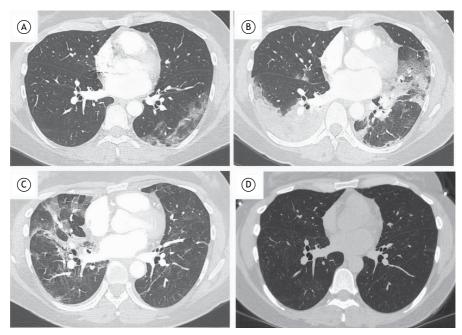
HRCT scans taken 14 days, 24 days, and 33 days after the onset of COVID-19 symptoms (in A, B, and C, respectively) and showing progressive migratory pulmonary infiltrates consistent with organizing pneumonia. In D, HRCT scan showing resolution of the pulmonary infiltrates 92 days after the onset of COVID-19 symptoms.
